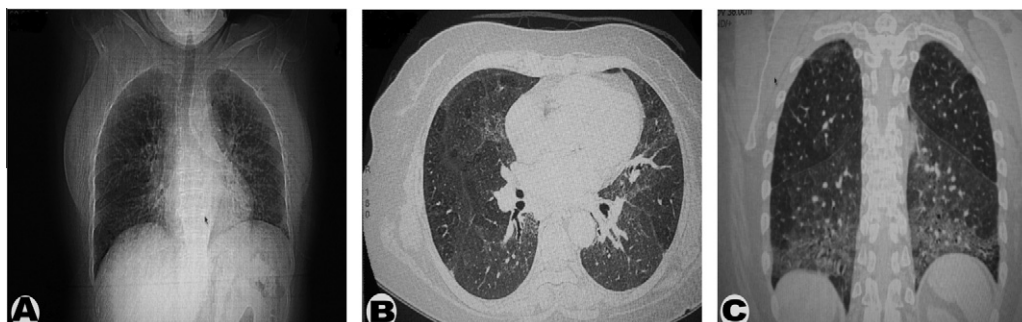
Female patient 14 years old suffered from chest pain and grade II dyspnea, her PFTs showed a restrictive pattern, (A) plain chest shows accentuated lung markings, (B) axial CT scan of demonstrates ground-glass attenuation of both lungs, (C) coronal MPR image shows basal tiny cystic changes.
